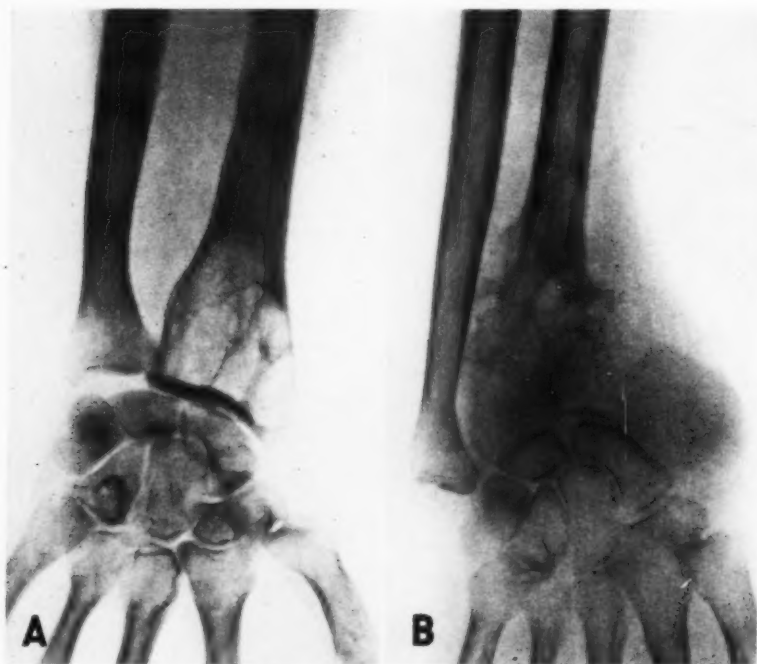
A. Radiograph showing osteoclastoma at lower end of radius. B. Radiograph of same wrist nine months after curetting.
